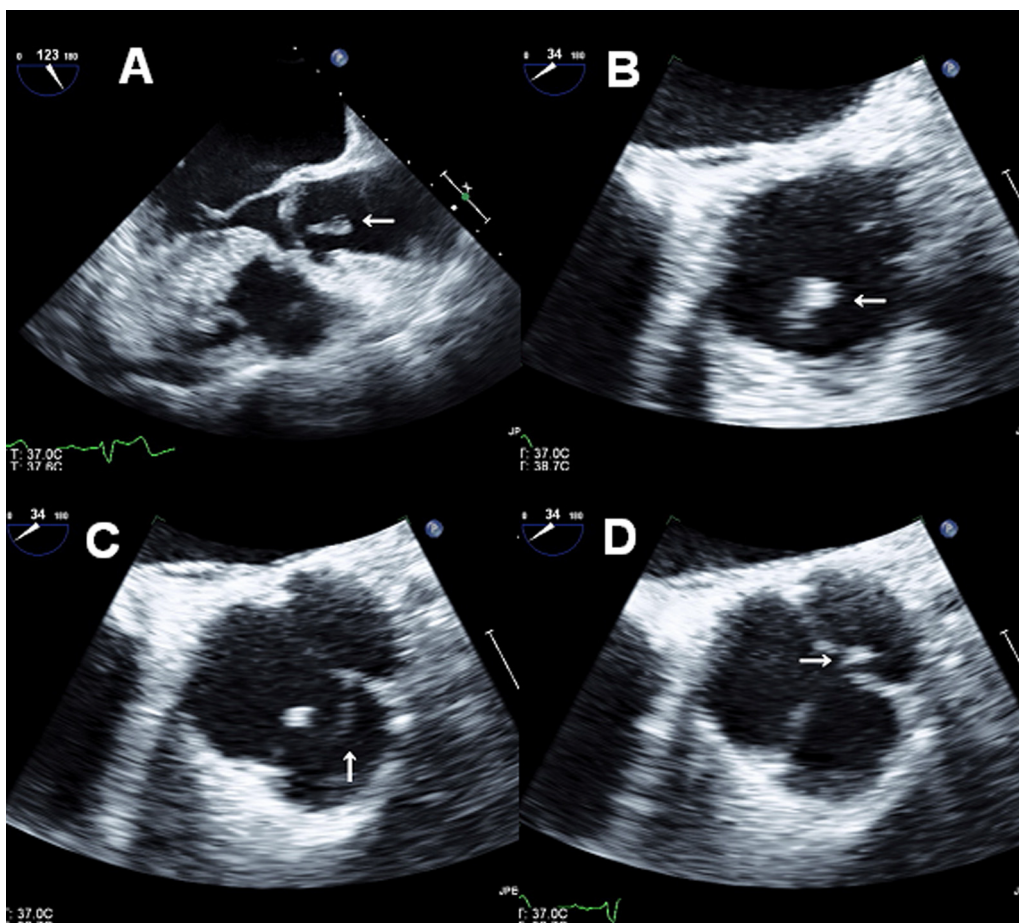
(A) Two-dimensional transesophageal long-axis view showing a hyperechoic mass attached to the non-coronary cusp of the aortic valve (arrow). (B) Transesophageal short-axis view (magnified at the aortic valve) showing a hyperechoic mass attached to the non-coronary cusp of the aortic valve (arrow). (C) Transesophageal short-axis view (magnified at the aortic valve) showing a hypoechoic mass attached to the right coronary cusp of the aortic valve (arrow). (D) Transesophageal short-axis view (magnified at aortic valve) showing a hyperechoic mass attached to the left coronary cusp of the aortic valve (arrow).
